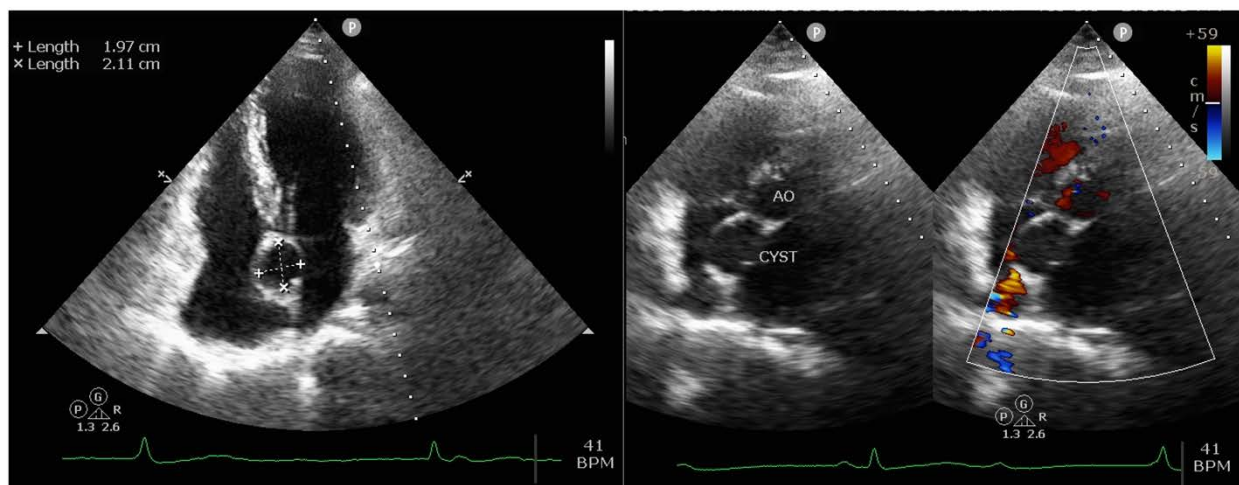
Echocardiography showed a cystic mass 1.97 x 2.11 centimeters of size in the interatrial septum close to the non-coronary cusp.
